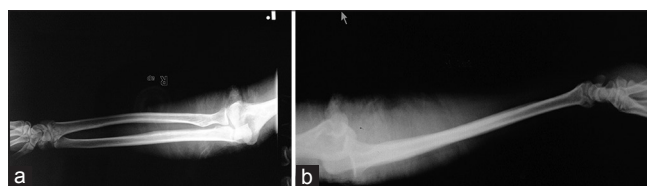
(a and b) Radiographs showing posterior dislocation of the elbow with fracture of the distal radius
